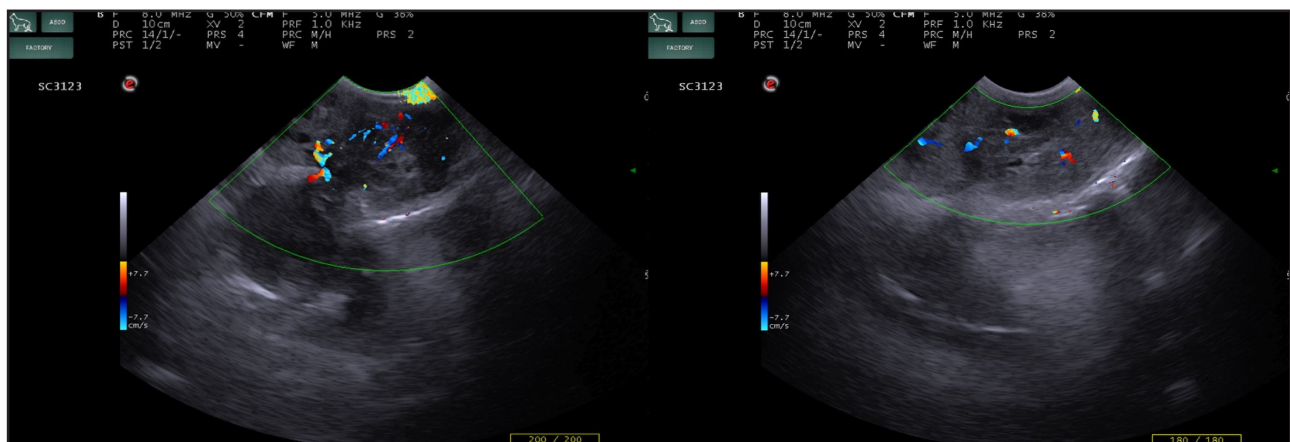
Color Doppler images of the primary mass obtained Pre-T and Post-T solution infiltration.
